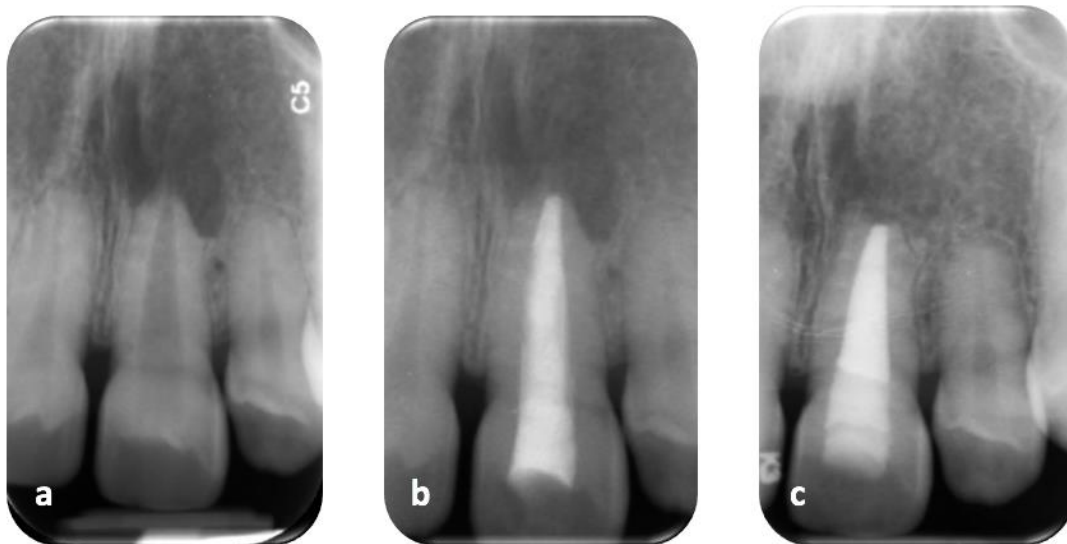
PA radiographs. (a) Pre-operative radiograph of tooth 21 (b) Postoperative radiograph (c) 1 year post apical microsurgery
